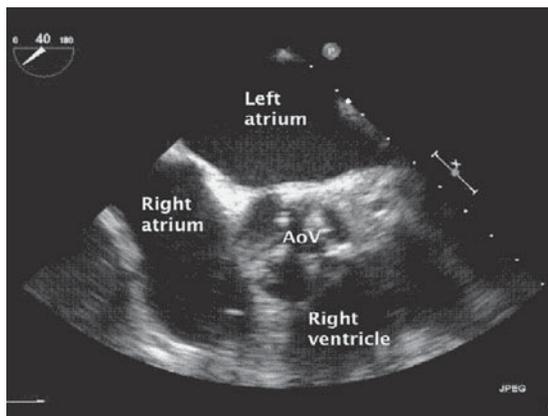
A stenotic aortic valve is clearly seen in this midesophageal short axis aortic valve view. Calcification of the aortic valve is usually associated with senile degeneration. However, congenitally abnormal (bicuspid) and rheumatic presentations also occur. (Reproduced, with permission, from Wasnick J, Hillel Z, Kramer D, et al: *Cardiac Anesthesia & Transesophageal Echocardiography*, McGraw-Hill, 2011.)
